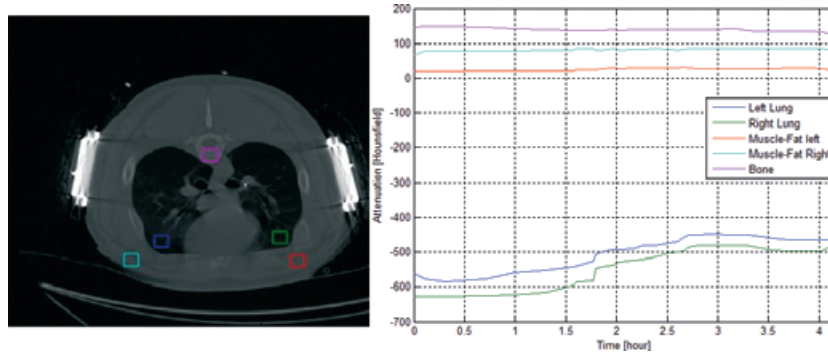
Three-dimensional analyzed regions of interest (ROIs) were defined in several areas. The purple, cyan, and red color-coded ROIs are outside the lungs, and the blue and green color-coded regions are within the left and right lungs, respectively. Note that gradual fluid overload is observed on computed tomography only in the lungs.
